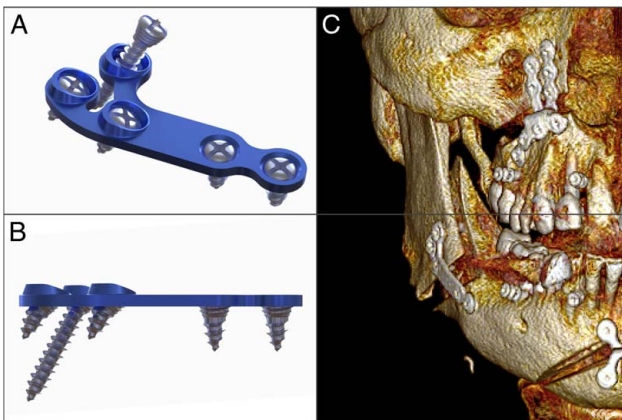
(A and B) 3D views of the mandibular plate showing the angle of inclination of the posterior locking screws. (C) Immediate postoperative 3D CT reconstruction showing the example of a bicortical locking screw in the most superior slot, which is the safest position in relation to the mandibular nerve. 3D indicates 3 dimensional; CT computed tomography.
